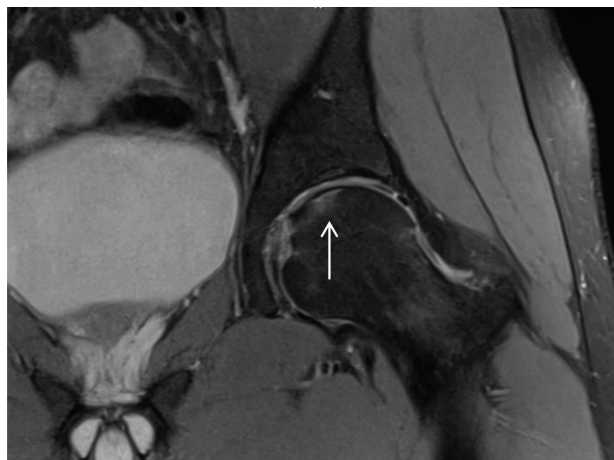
New MR images taken a month after the patient remained non-weight bearing. Subchondral abnormalities and bone marrow edema are evident (arrow mark).
